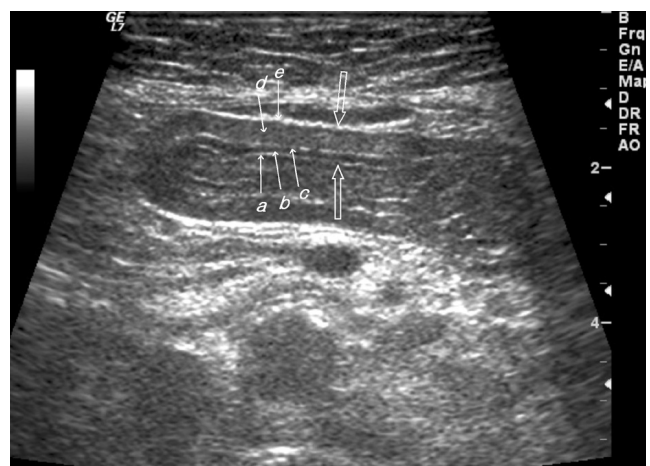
Transabdominal ultrasonography in a normal patient. The longitudinal scan image shows normal gastric wall with a five layer structure. The thickness (open arrows) of gastric wall measured about 5 mm. a = first hyperechoic layer representing the interface between gastric fluid and the mucosal surface. b = second hypoechoic layer representing the mucosal muscle. c = third hyperechoic layer representing the submucosa. d = fourth hypoechoic layer representing the muscle proper. e = fifth hyperechoic layer representing serosa and serosal fat.
